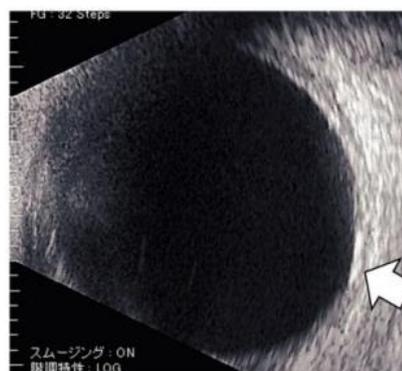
Ultrasonic B-scan echography
